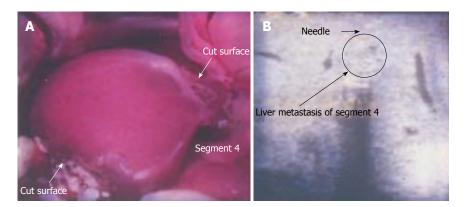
Intraoperative findings. A: She underwent right hepatectomy with lateral segmentectomy and partial resection of segment 1. B: Intraoperative ultrasonography detected two small nodules in segment 4, which were treated with intraoperative microwave coagulation therapy.
